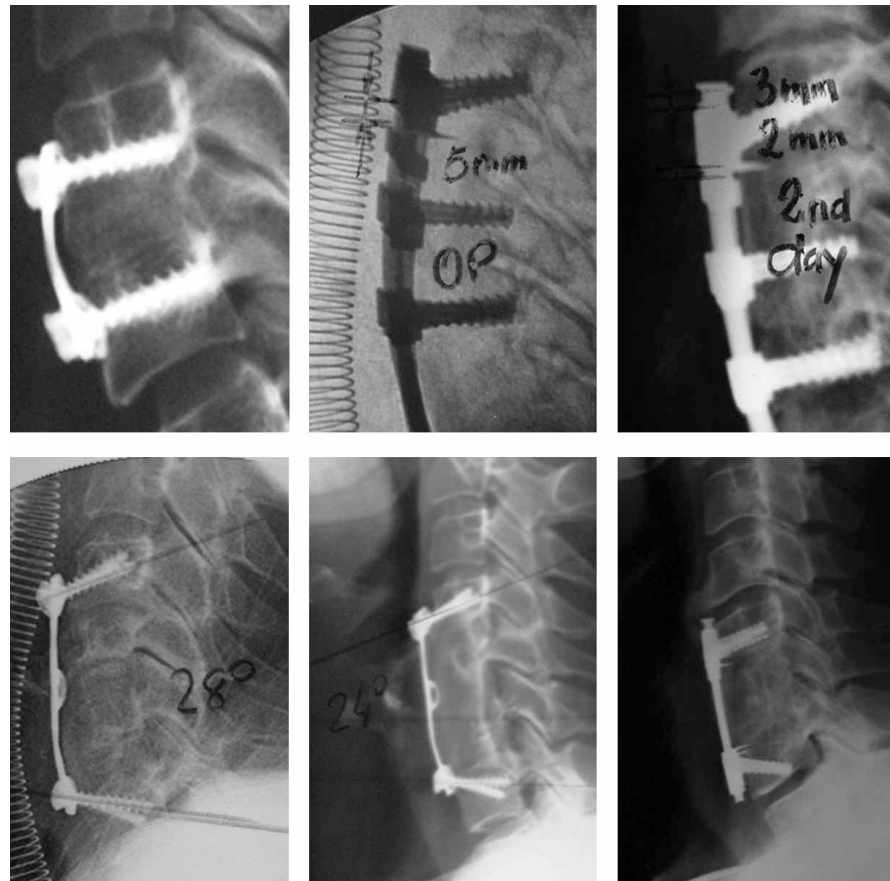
Upper-left: trabeculation and space obliteration of upper and lower end-plate represent grade 1 according to Tribus classification. Upper-center and right: natural settling under dynamic implants occurred in the first two postoperative days. Lower-left and center: rotation of 4 degrees was noticed on the 6-week follow-up X-ray after two-level corpectomy. Lower-right: vertical rods axial telescoping with overlapping of supradjacent segment induced heterotopic ossification.
